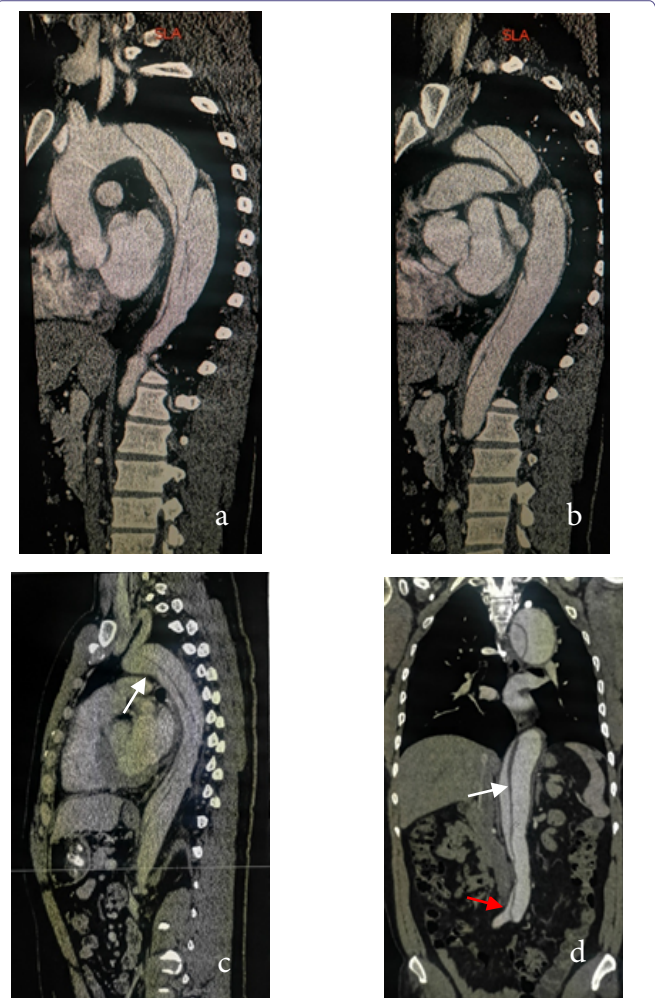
Sagittal (a-b-c) and coronal (d) reconstruction aortic CT angiography images with arterial contrast shows an intimal flap (with arrow) in the thoracic aorta, with extension into the iliac bifurcation (red arrow).
